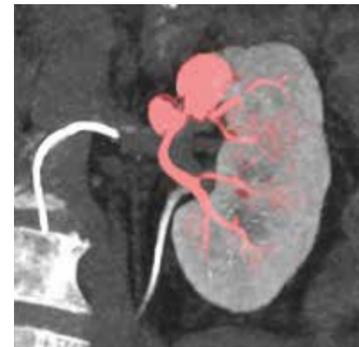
CT late venous phase to check encroachment
